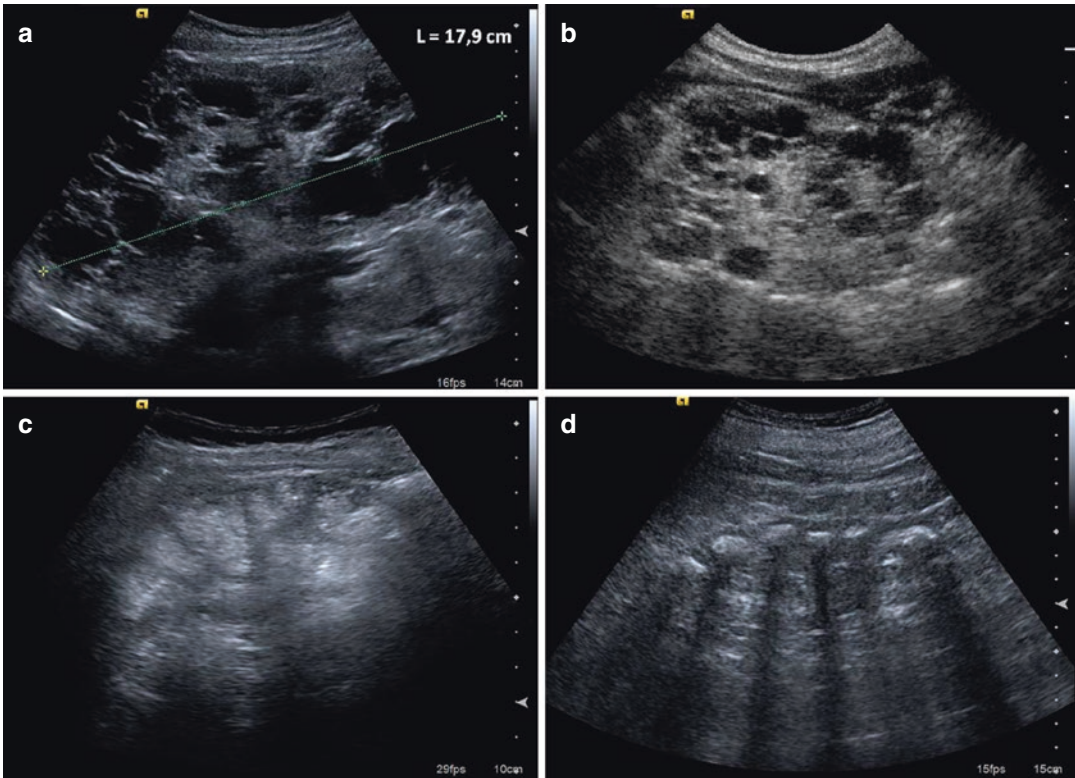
Structural abnormalities as markers of chronic kidney damage. (a) Adult polycystic kidney disease (ADPKD) is an autosomal dominant progressive disorder characterized by cyst formation and enlargement in the kidney, diagnosed by ultrasound as multiple anechoic cysts impairing adult renal parenchyma. (b) In multicystic
